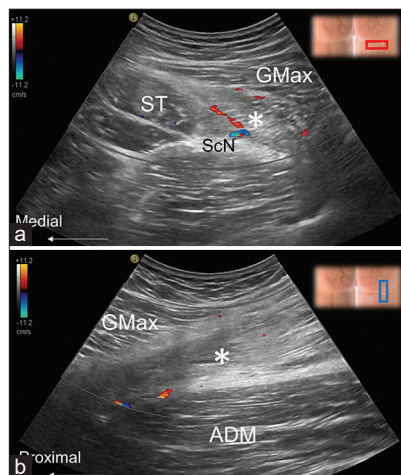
Ultrasound images over the proximal posterior thigh at the painful site at the short- (a) and long-axis (b) views. ST: Semitendinosus, GMax: Gluteus maximus, ADM: Adductor magnus; white asterisk, the lesion
